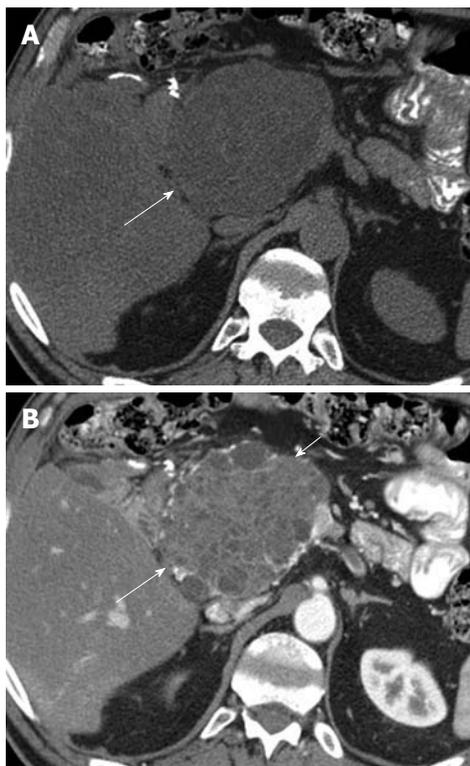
A 62-year-old man with history of epigastric discomfort. A: Axial non-contrast computed tomography (CT) of the abdomen shows a mass in the pancreatic head (long arrow); B: Axial contrast-enhanced CT of the abdomen shows enhancement within the mass (long arrow) and cystic components (short arrow) suggestive of a microcystic serous cystadenoma.
